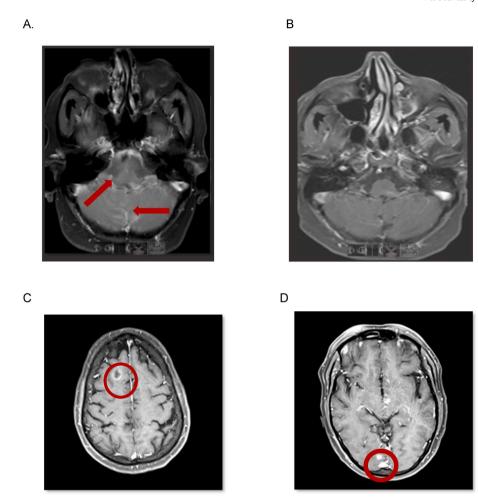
(A) Magnetic Resonance Imaging (MRI) Brain (May 2024) depicting evidence of leptomeningeal disease. (B) MRI brain (July 2024) depicting resolution of the leptomeningeal disease. (C) Axial post-contrast T1-weighted MRI showing a new ring-enhancing lesion in the right frontal lobe. (D) Axial post-contrast T1-weighted MRI depicting an enhancing lesion in the left occipital lobe.
